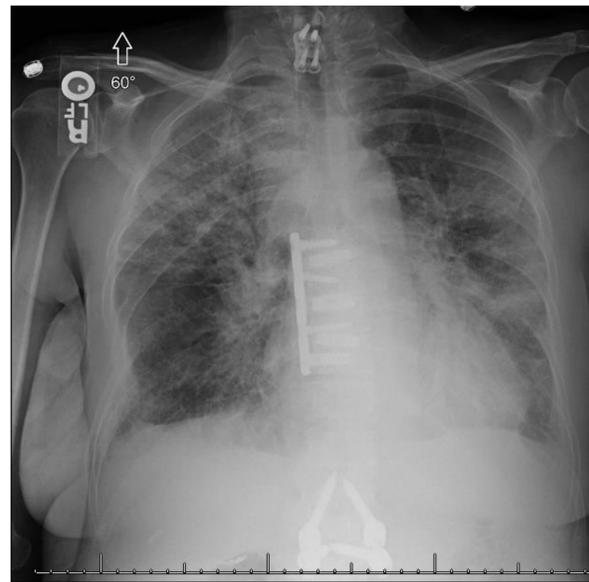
Chest radiograph upon ICU admission. Notable for diffuse bilateral hazy opacities with an upper lobe predominance.
